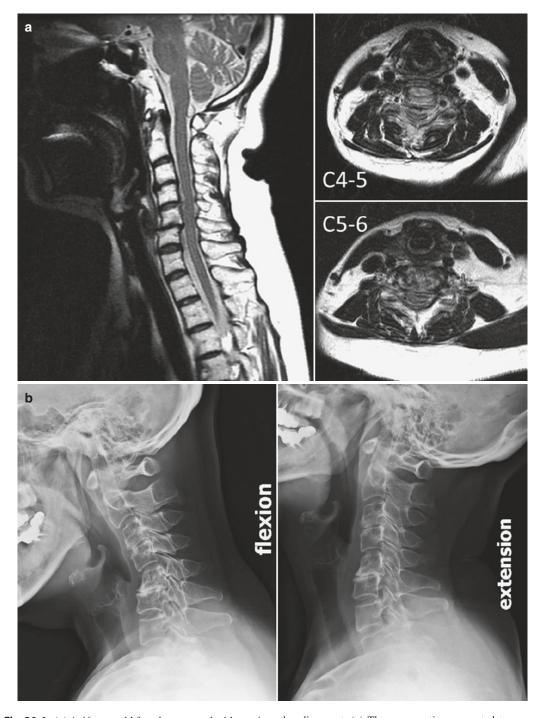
(a) A 46-year-old female presented with cervical myeloradiculopathy caused by disc herniation at the levels of C4–C5 and C5–C6. There were retrolisthesis and instability at C5–C6 which would preclude a successful cervical disc arthroplasty. (b) The lateral flexion and extension radiographs demonstrated possible instability at C4–C5 and marked deformity at C5–C6, which indicated that the cervical disc arthroplasty was unlikely to restore
